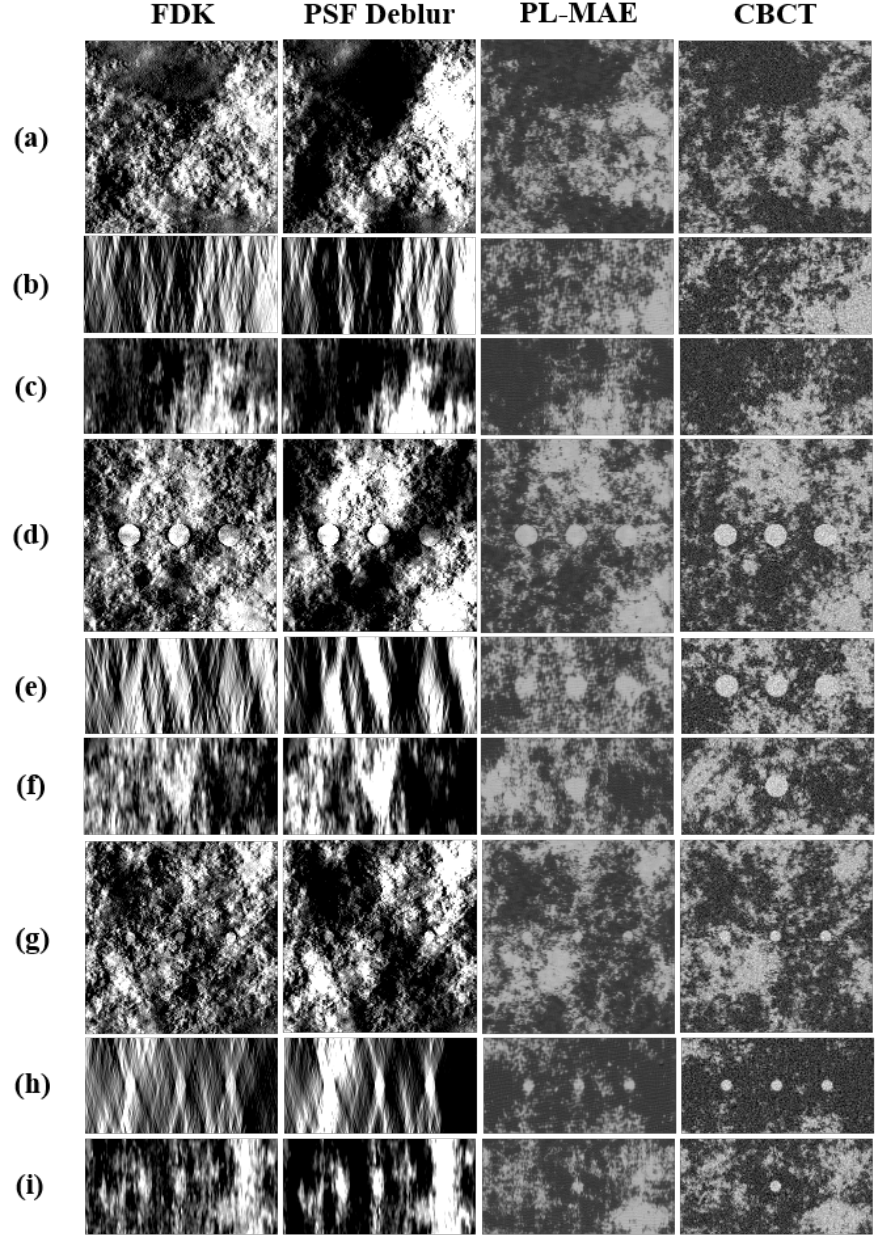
Results for further clarification. Comparison of DBT images reconstructed by FDK, deblurred images by PSF deblur method, deblurred images by the proposed method with PL-MAE loss function, and CBCT images (from left to right). Images without mass lesion for (a) axial, (b) coronal, and (c) sagittal planes; images containing 4 mm lesions for (d) axial, (e) coronal, and (f) sagittal planes, and images containing 2 mm lesions for (g) axial, (h) coronal, and (i) sagittal planes. The display window is $[0.03 \ 0.10]$ in cm^{-1} .
